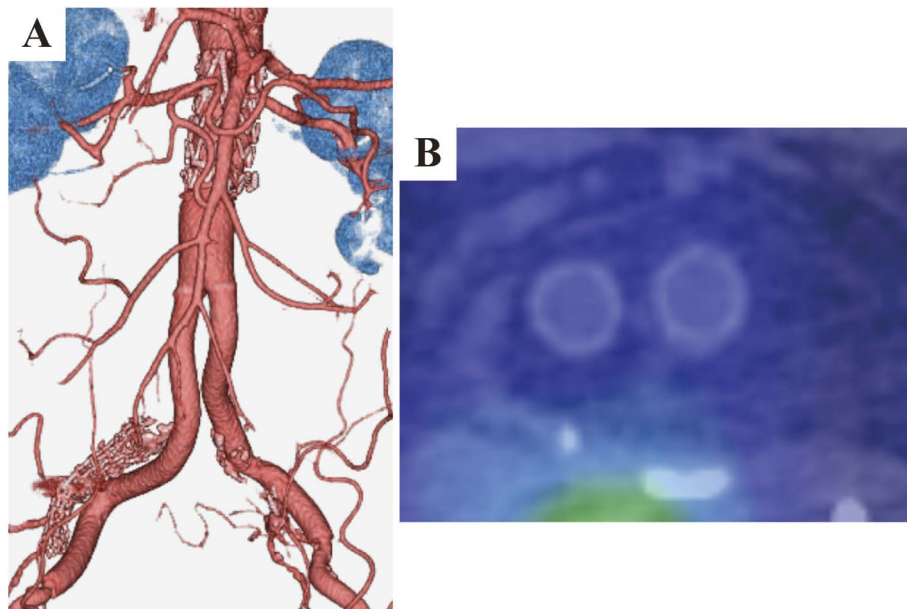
Imaging after surgical removal of the stent graft and in situ revascularization. (A) A three-dimensional computed tomography (CT) image. The expanded polytetrafluoroethylene (ePTFE) graft was anastomosed to the native aorta and the remaining part of the Endurant main body. (B) A Ga-67-citrate single-photon emission computed tomography (SPECT)/CT fusion image. There was no sign of fluid accumulation around the ePTFE graft.
